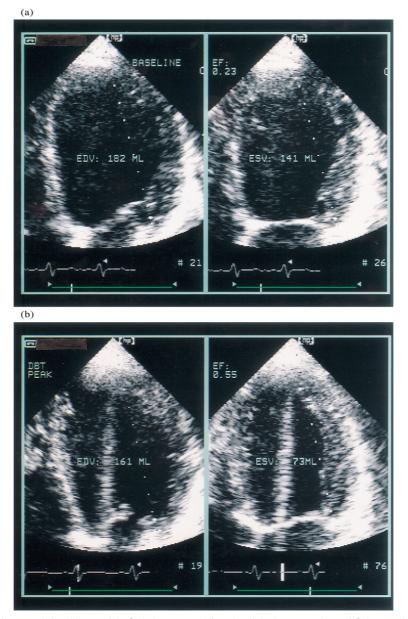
Echocardiographic frames of the left ventricle (left frame, end-diastole; right frame, end-systole) from apical four-chamber view in a study patient with IDCM and positive response to DET: (a baseline study; and (b) control at the end of dobutamine infusion ( $20 \mu g/kg min$ ). At the baseline study, the EF was severely depressed (23%), but significantly improved during DET (55%).
